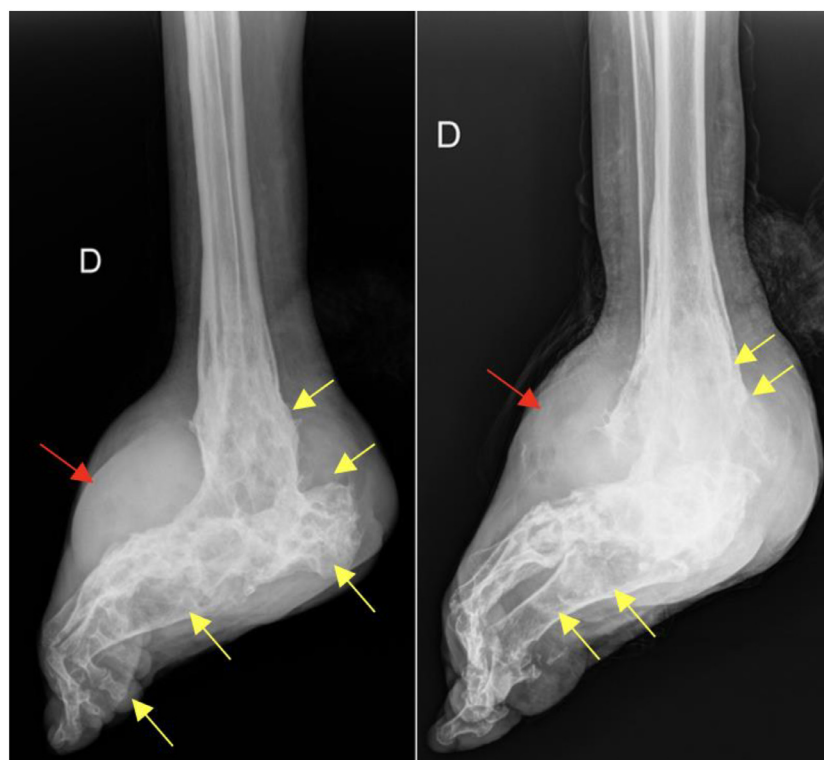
Radiographs of the right foot showing soft tissue enlargement (red arrows) and bone deformity with erosions and osseous destructive changes extensively involving the distal tibia, hindfoot, and midfoot bones (yellow arrows).
